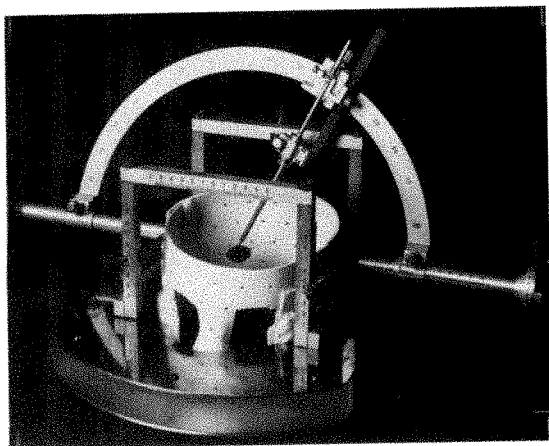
Procedure for attaching Leksell stereotaxic instrument to fixation device. Coordinates of target point obtained at CT scanning are directly transferred to this system without reference to anatomical landmarks.
